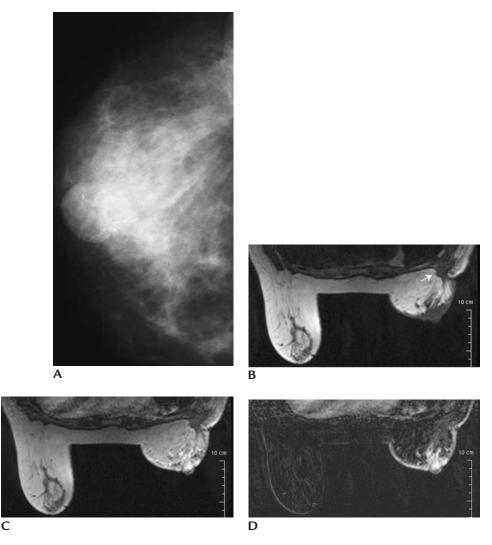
Recurrent invasive ductal carcinoma following right lumpectomy. (A) Mammogram demonstrates dense tissue. Lumpectomy site posterolaterally is not adequately imaged mammographically (tissue cannot be pulled into image). (B) Axial T1-weighted image precontrast demonstrates lumpectomy site (*arrow*) posterolaterally in the right breast. Also apparent is marked skin thickening anteriorly. (C) Axial T1-weighted image following bolus of contrast demonstrates rapid initial enhancement of tissue anteriorly in the subareolar area and skin with washout (subsequent images not shown). No enhancement is apparent at the lumpectomy site. (D) Subtraction image.
